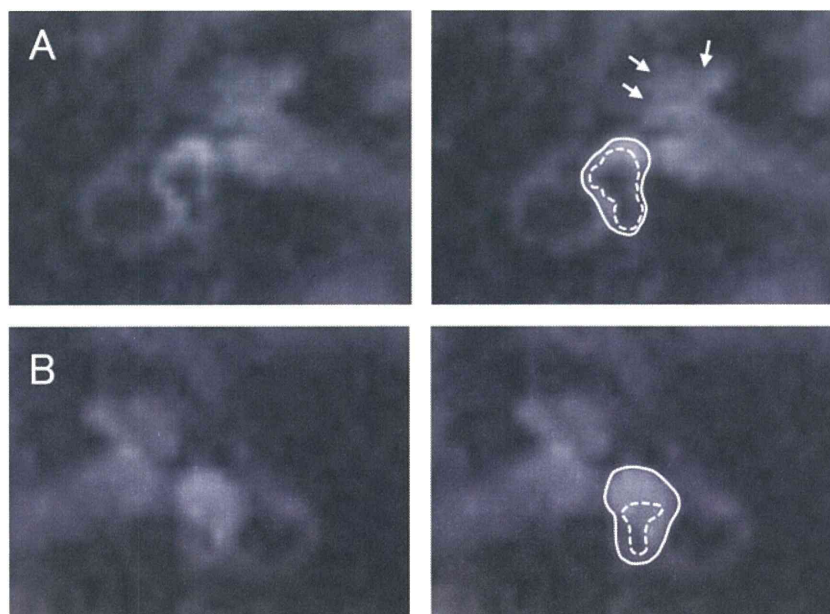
3D FLAIR MRI of patient no. 3. Significant hydrops was observed in the cochlea (arrows) and vestibule of the diseased ear (A). The dotted line indicates the endolymphatic space and the solid line indicates the total fluid space in the vestibule. No hydrops was visible in the cochlea or vestibule of the contralateral ear (B).
